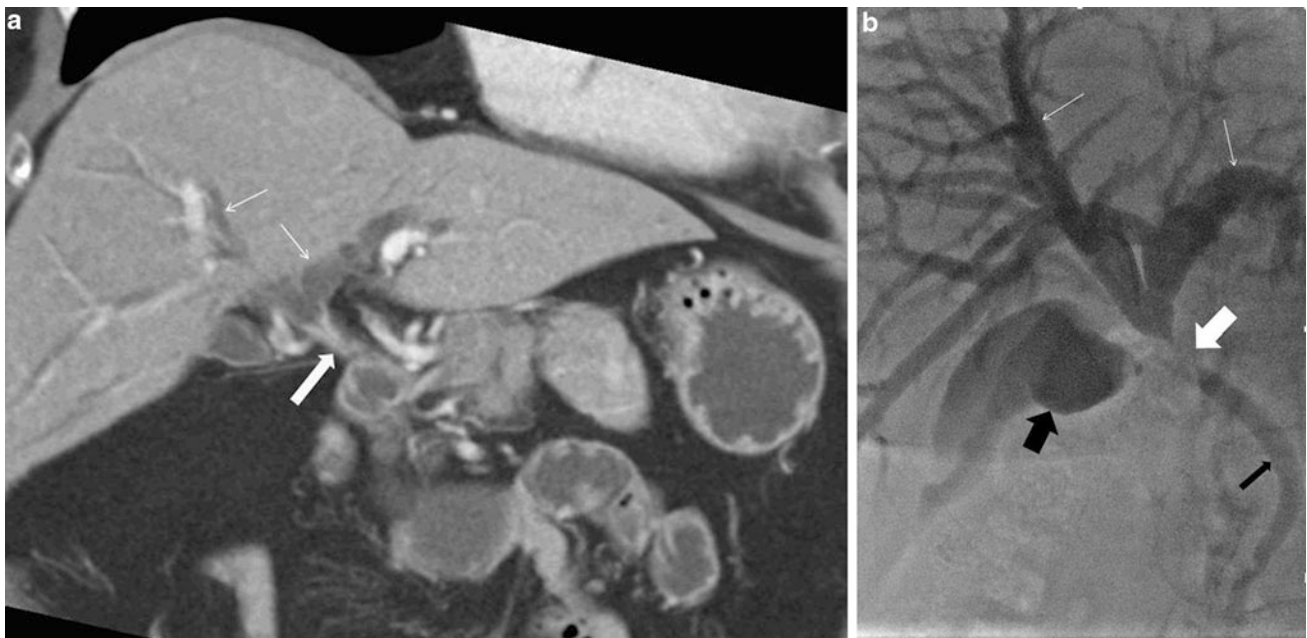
Cholangiocarcinoma. a Coronal view reconstruction of contrast-enhanced CT shows a stricture with enhanced wall thickening of the common hepatic duct (*thick arrow*) and intrahepatic bile duct dilatation (*thin arrows*). b A stricture of the common hepatic duct
